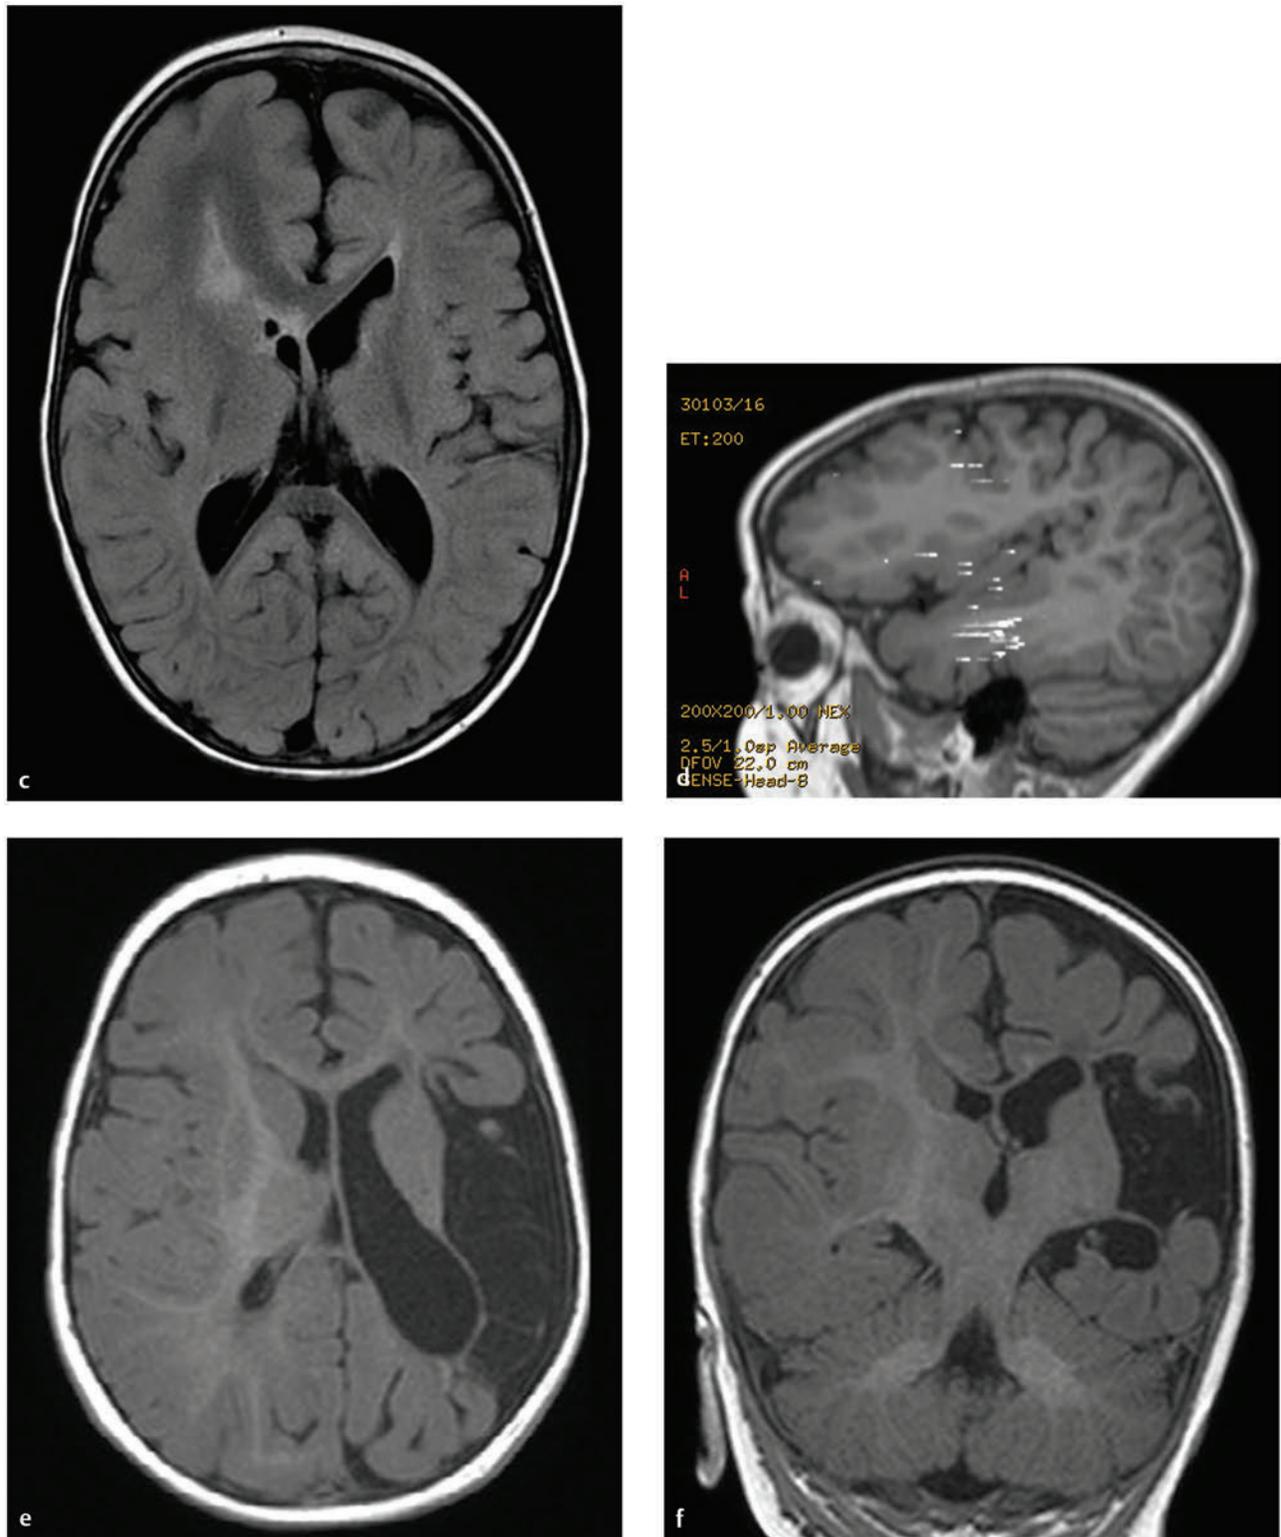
(continued) (c,d) Axial FLAIR (fluid-attenuated inversion recovery) MR image and magnetoencephalogram of hemimegalencephaly. (e, f) Axial and coronal T1-weighted MR images of perinatal middle cerebral artery infarct.
